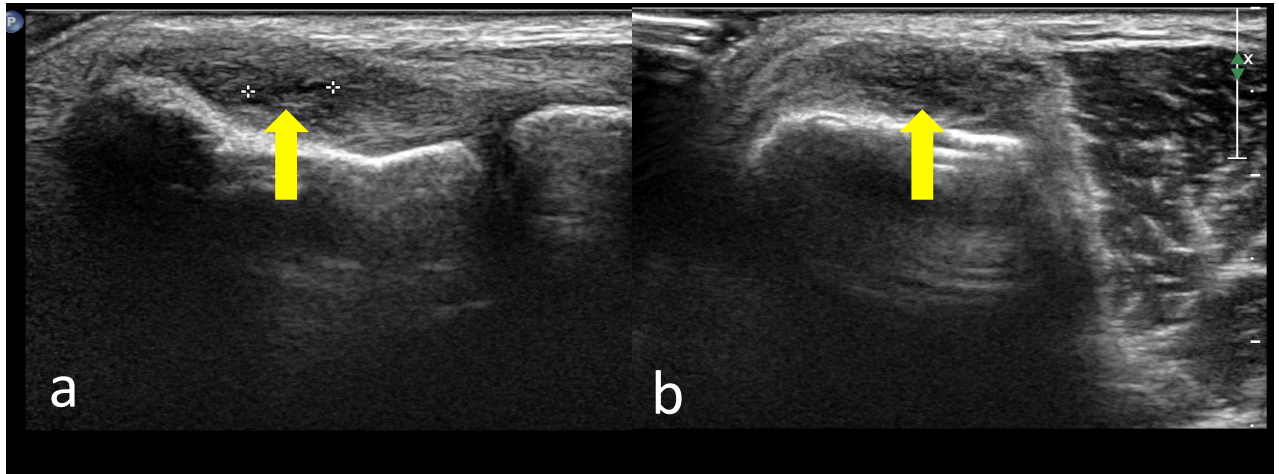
Ultrasound image of a pathological common extensor tendon of the elbow. (a) Longitudinal and (b) transverse image reveal a focal intratendinous hypoechoic lesion (yellow arrow)
